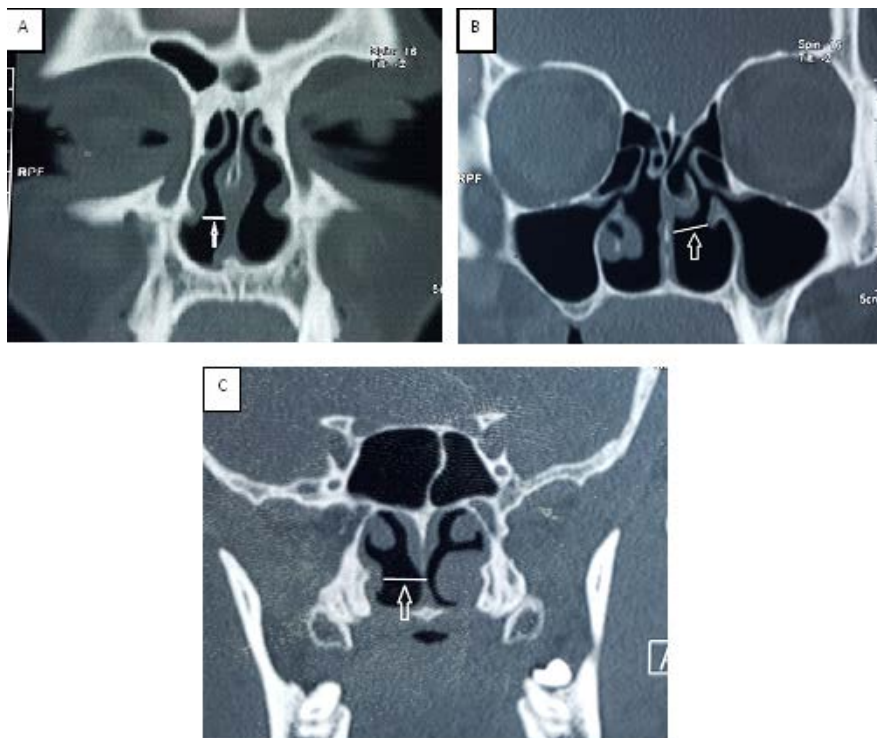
Nose and paranasal sinus coronal computed tomography images obtained 6 months after traditional surgery of the inferior turbinate. (A) Level 1: increased nasal cavity distance (arrow). (B) Levels 2 and (C) 3: increased nasal cavity space (arrows).
